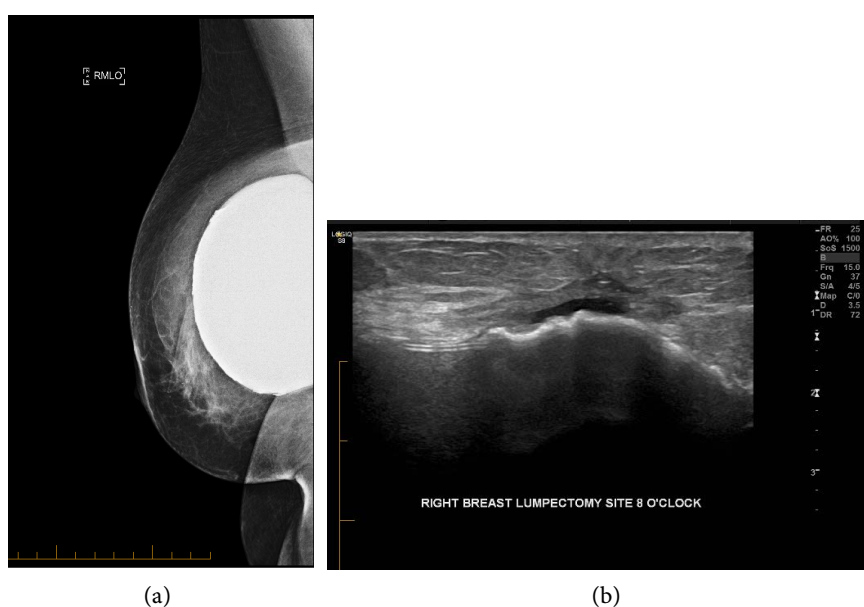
(a) Single MLO mammographic projection of the right breast, 18 months following lumpectomy, shows no evidence of cancer recurrence. There is thick capsular calcification of the implant periphery, as was seen pre-operatively. (b) Sonography performed 18 months post-lumpectomy shows a typical trace seroma in the lumpectomy bed, and thick capsular calcification, but no evidence of recurrence or implant rupture.
